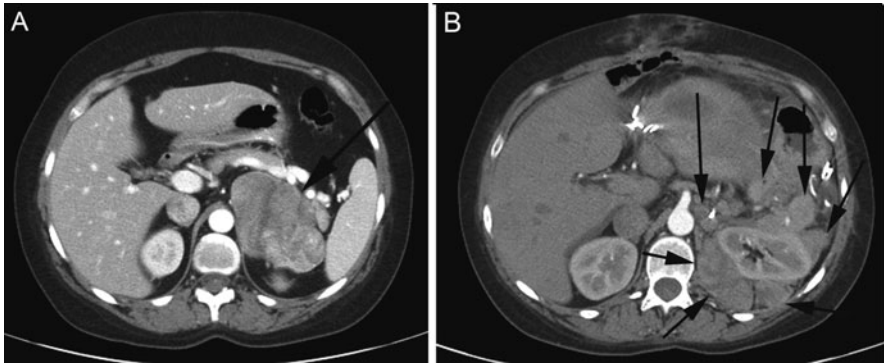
Preoperative (a) and 6-month postoperative (b) CT scans in a patient with an apparently localized ACC. The operation was marked by fracture and spillage of the tumor, with malignant contamination of the peritoneal cavity. The preoperative scan showed a large but focal process (*large arrow*) while the postoperative scan shows multiple foci of recurrence
